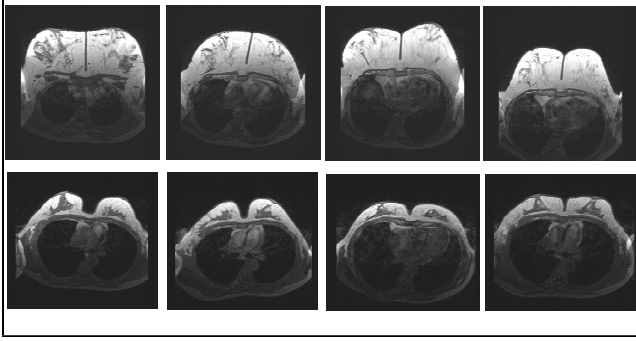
Baseline (column 1) and 3 follow-up MR images (column 2, 3, 4) of two patients undergoing neoadjuvant chemotherapy, depicting variations in breast shape, between studies.
